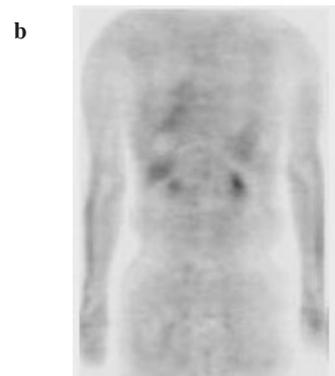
Chest CT and FDG-PET imaging performed at 2 days and 5 days, respectively, after radiotherapy. (a) Enhanced chest CT showing a residual mass. (b) No intensive FDG uptake was shown by coronal FDG-PET imaging.
